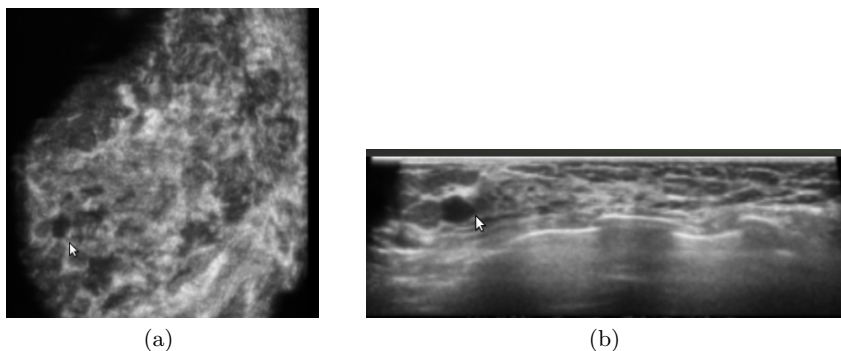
A benign lesion in ABUS (indicated by the arrow). Two slices through the lesion are shown, a coronal slice (a) and a transversal slice (b). The latter is similar to the traditional 2D ultrasound view
